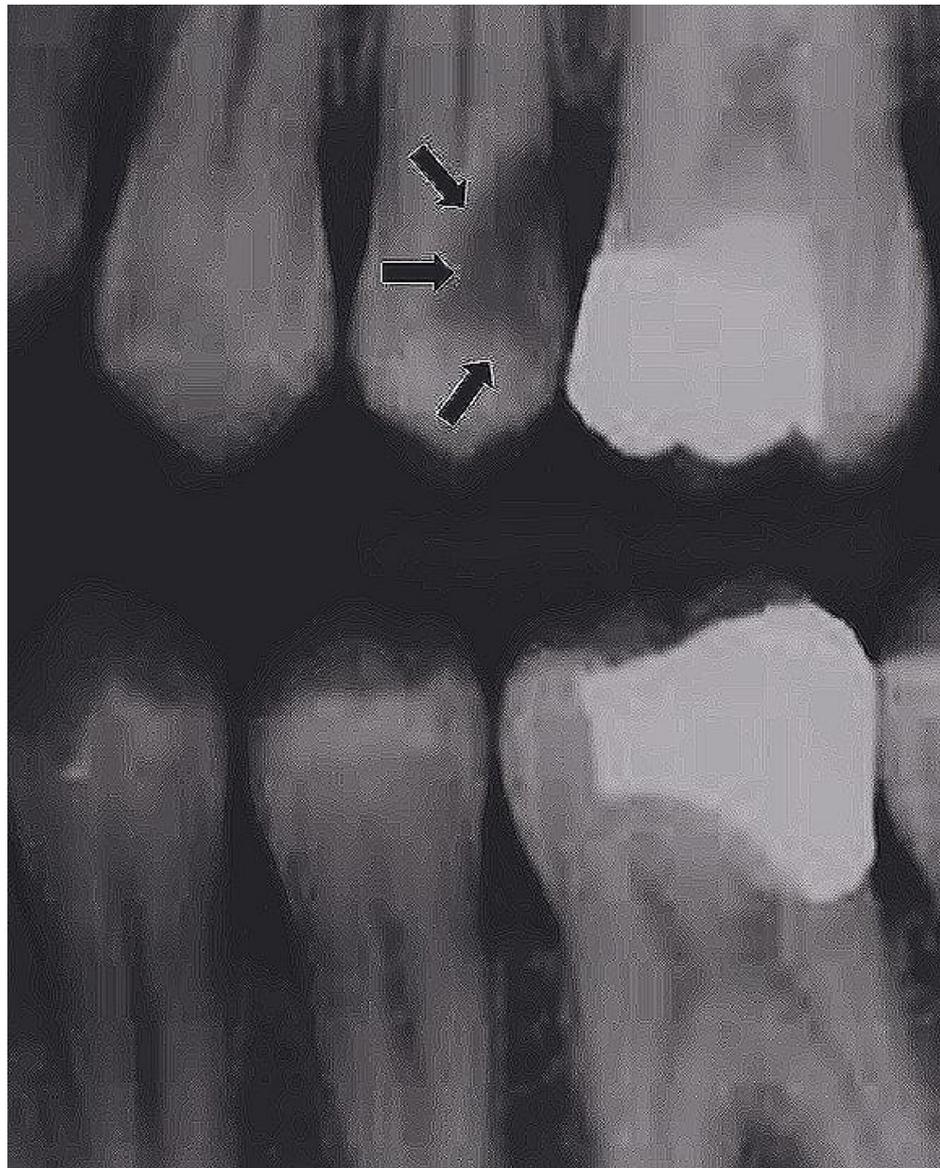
Pre op bitewing X-ray (arrows marking radiolucency on distal aspect of tooth #15 indicating class II lesion)
